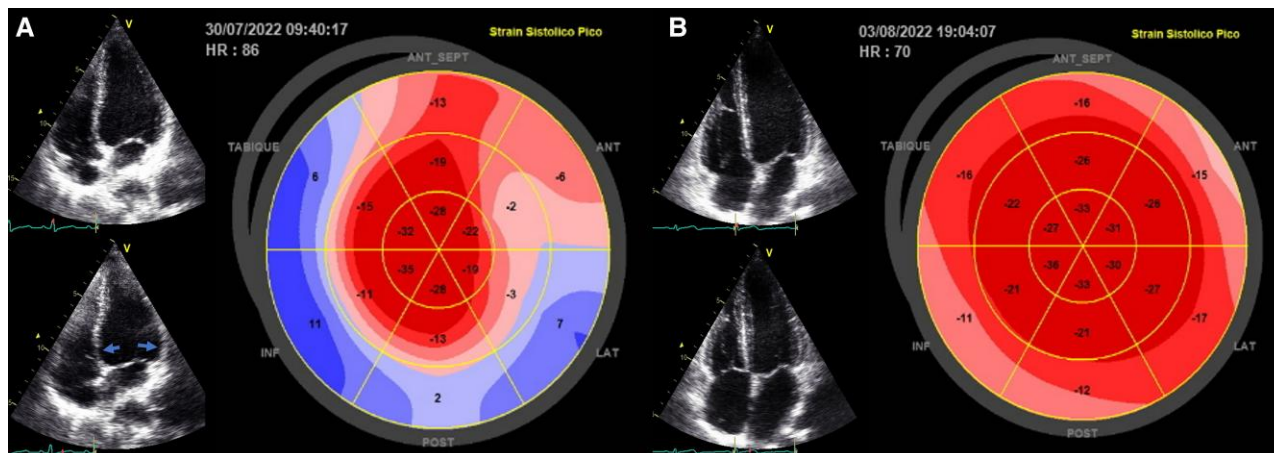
(A) Initial echocardiogram in the four-chamber view showing basal ballooning of the basal segment (arrows) with apex hypercontractility. The bullseye shows the left ventricular strain with severe systolic impairment of the basal segment and hypercontractility of the apex. (B) Follow-up echocardiogram showing almost complete recovery of systolic function, including strain.
